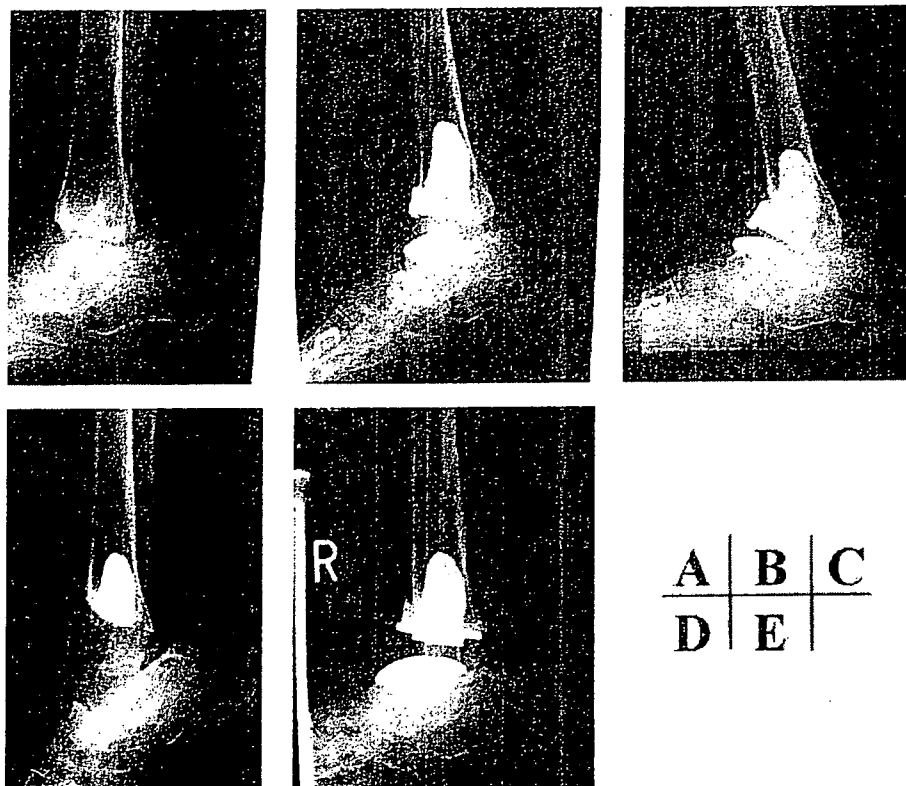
A case of a 64 year-old woman who demonstrated early loosening that necessitated a revision surgery 5 months after the initial surgery. However, no clear zone was observed between HA and bone on radiographs, and firm fixation between HA and the implanted site was confirmed during the revision surgery. (A) Before surgery. (B) After the initial surgery. (C) Loosening of the tibial component was noted. (D) Firm bonding of HA with the implanted site bone was noted after removal of the tibial component. (E) After the revision surgery.
